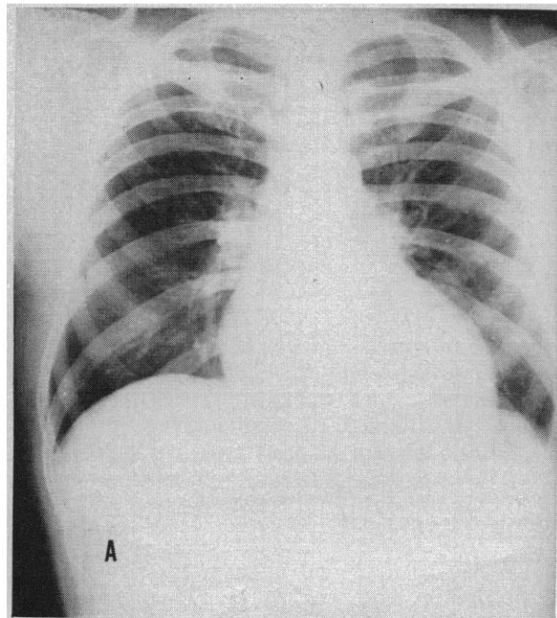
A, Chest x-rays of 46-year-old man on Dec 13, 1960, at admission to study program.
